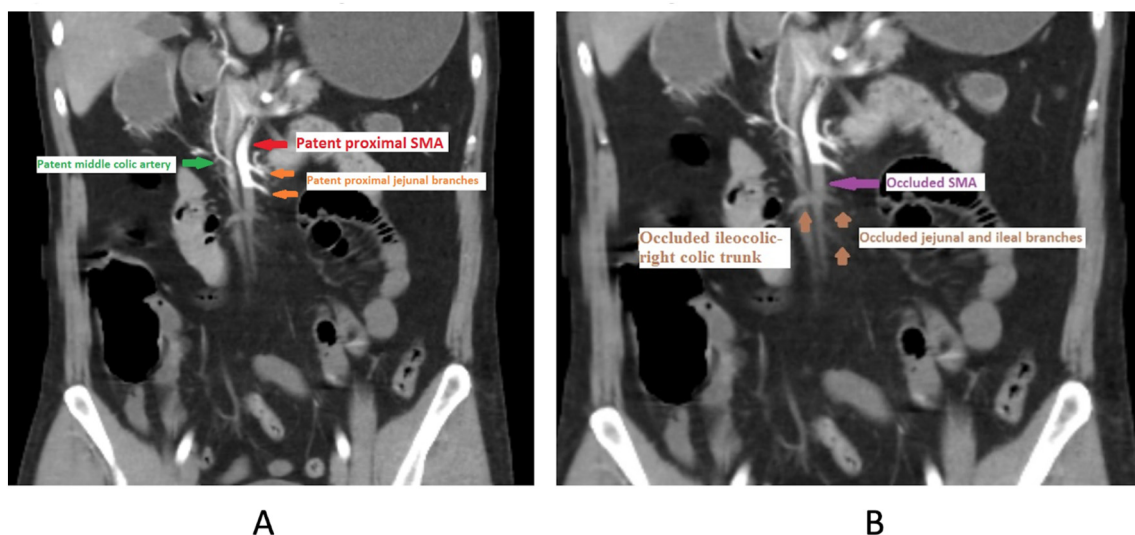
CTA demonstrating occlusion of the SMA, diagnostic of acute mesenteric ischemia [98].
